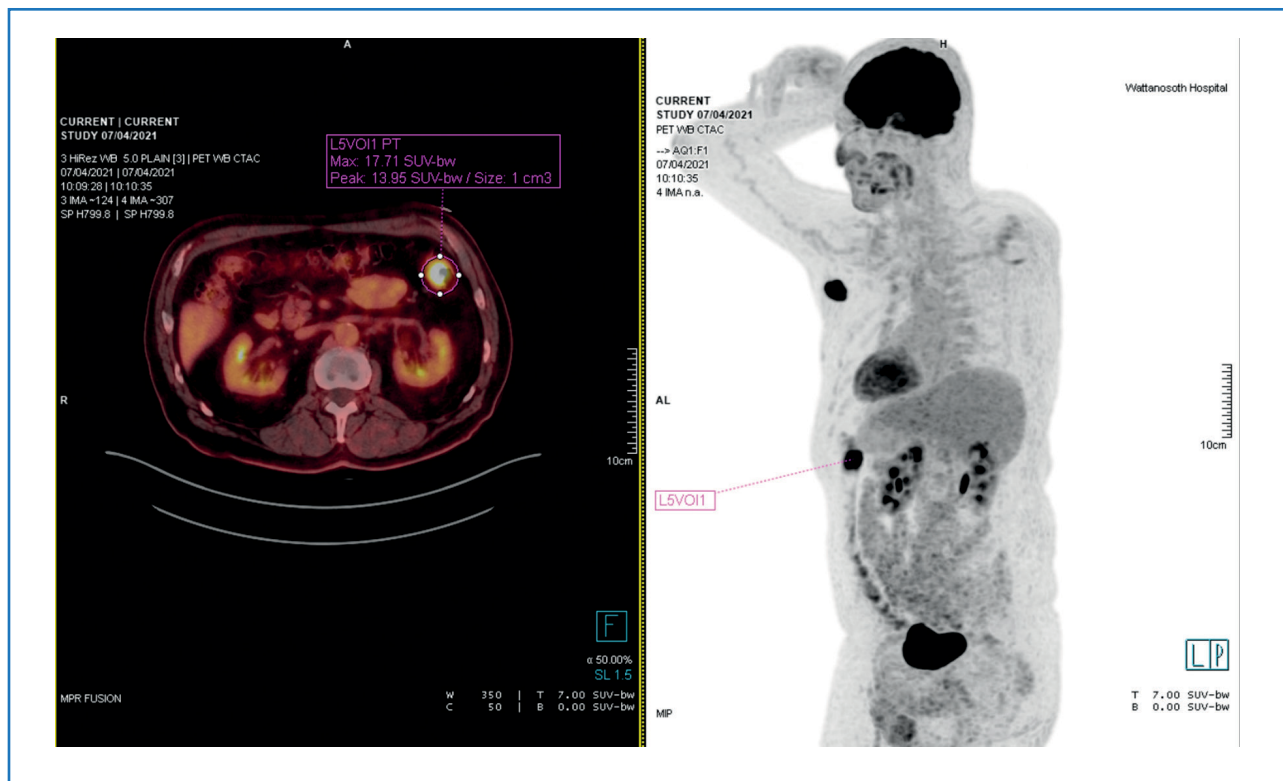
18F-FDG PET/CT showed hypermetabolic polyp in the proximal descending colon near the splenic flexure
